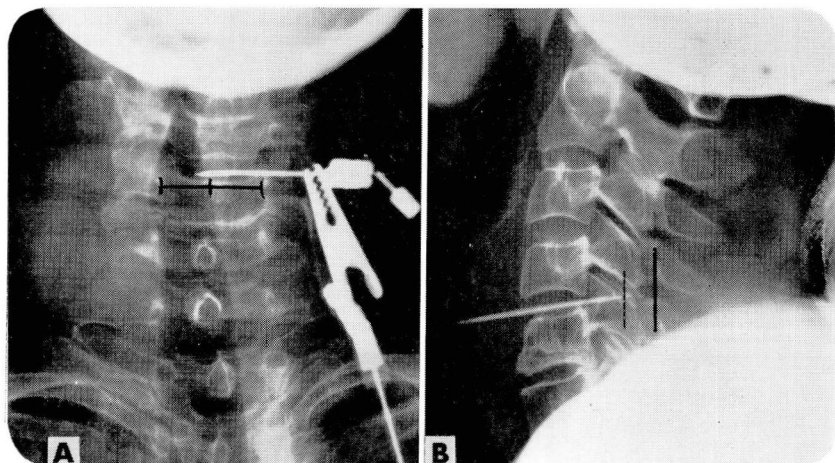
Roentgenograms of the lower cervical spine demonstrate the needle electrode inserted diagonally through the intervertebral disk to the target point within the spinal cord.
